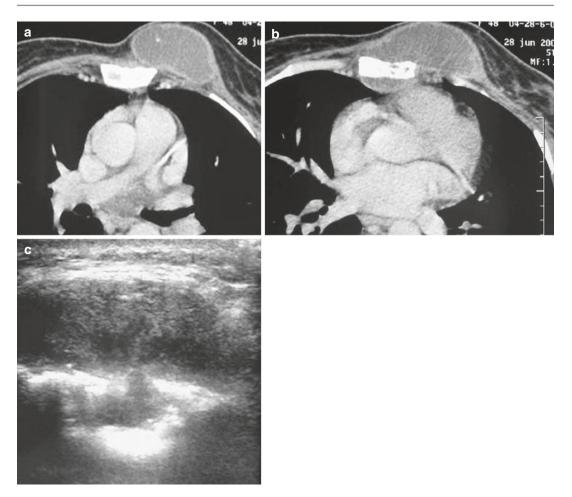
Tuberculous osteomyelitis involving the sternum and adjacent abscess: axial CT images (a, b) shows sternal osteolysis associated to pre- and retrosternal fluid
